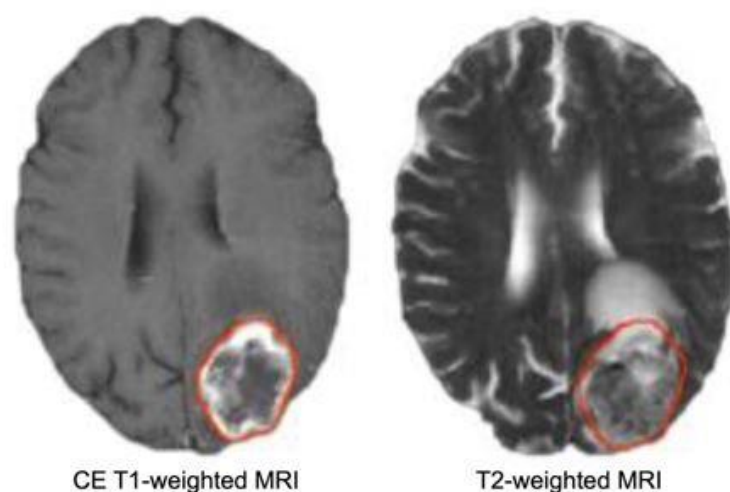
Features were extracted from contrast-enhanced (CE) T1- and T2-weighted MRI. Brain metastases were manually segmented (red contour) based on CE T1-weighted MRI.
